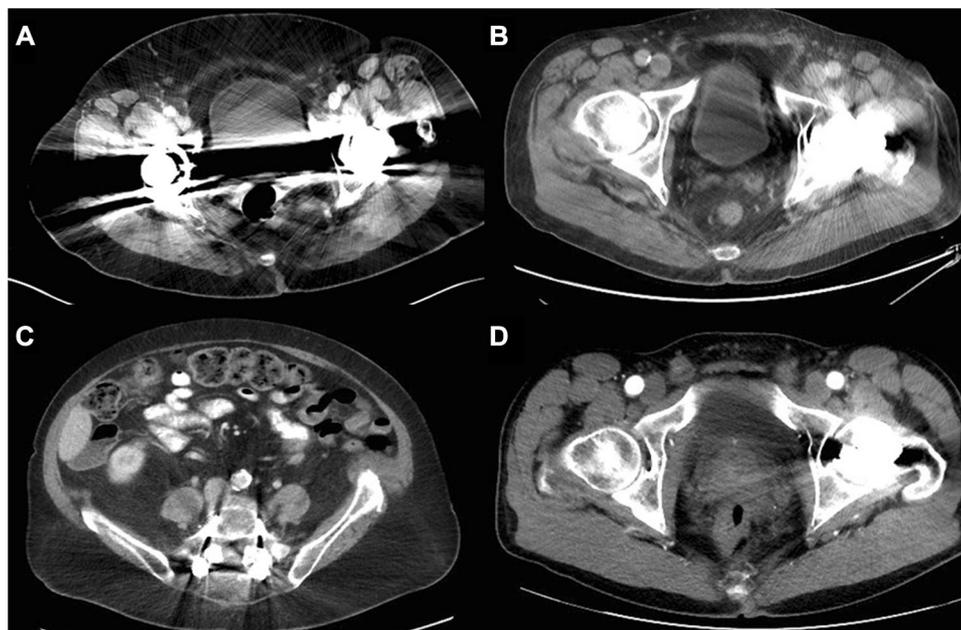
Orthopedic metallic hardware in abdomen and pelvis CT and the degree of artifacts. A Axial contrast-enhanced CT images shows bilateral hip implants producing most marked
